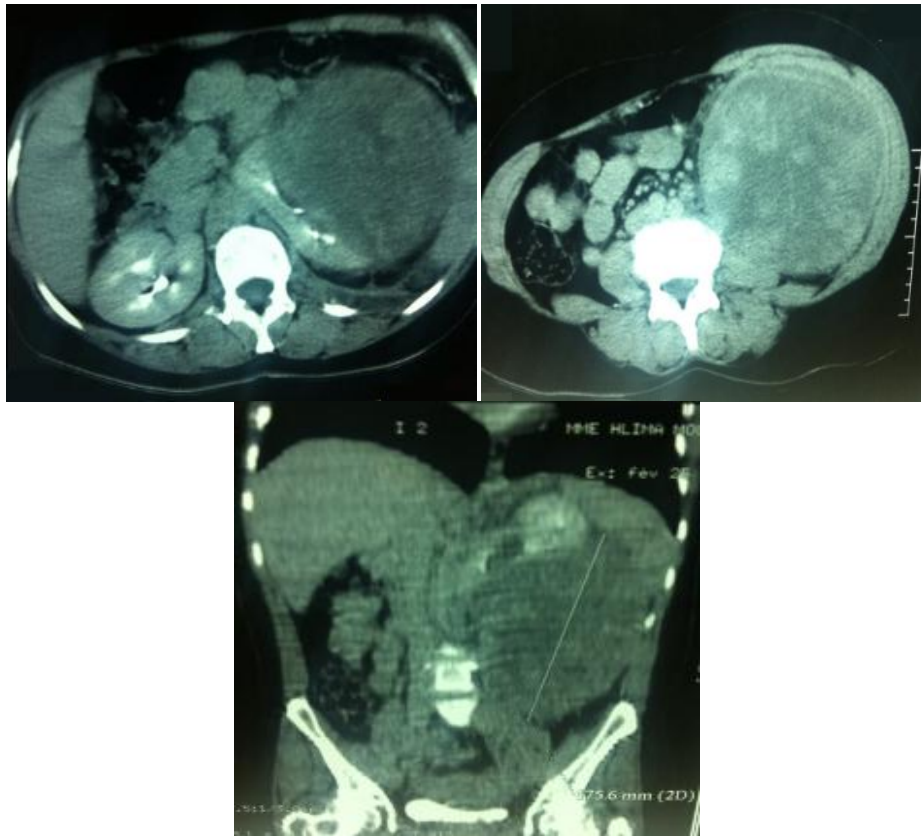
Computed tomography of abdomen showing left kidney with large heterogenous mass lesion involving the ipsilateral hilus
